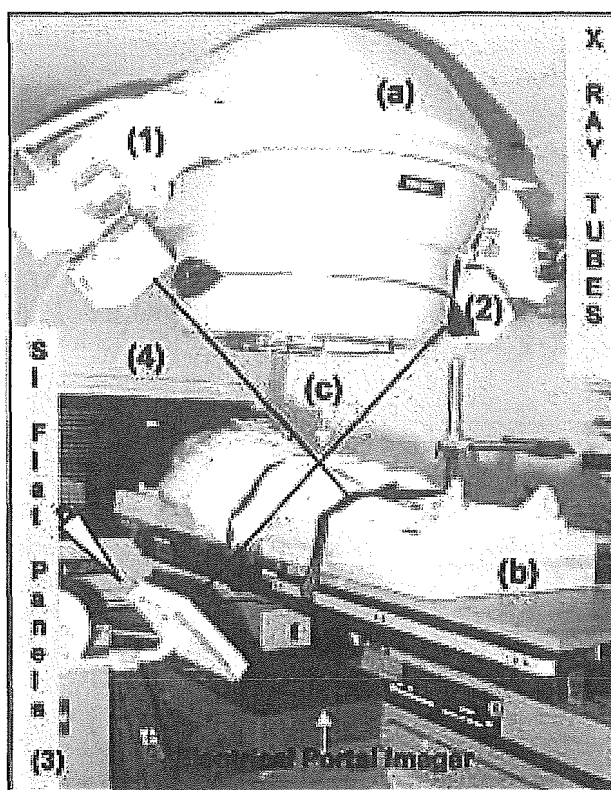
Dual fluoroscopy and paired flat panel system (a). Typical (supine) patient setup positioning used for CT and image-guided IMRT with external body fixation frame and vacuum cast (b). Isocentered gold marker (GS-1-iso) is aligned at the intersection between kv ray beam axis and accelerator isocenter (c). Shown are X-ray tubes (1, 2), a-Si flat panels (3), and Linac (4). CT = computerized tomography, SI = silicon.
